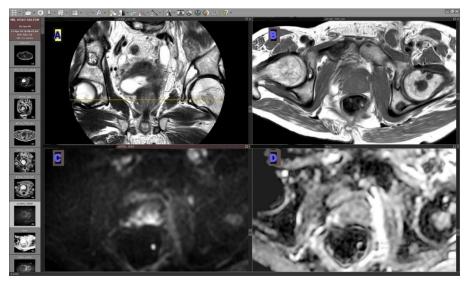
This image Includes T2W (A), T1W (B), DWI (C) & ADC (D) of prostate cancer
